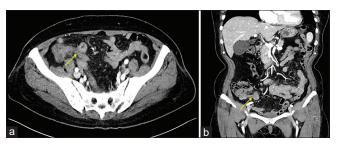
Pre-operative abdominal computed tomography scan of appendicitis with periappendiceal fluid collection. (a) Axial image. (b) Coronal image
